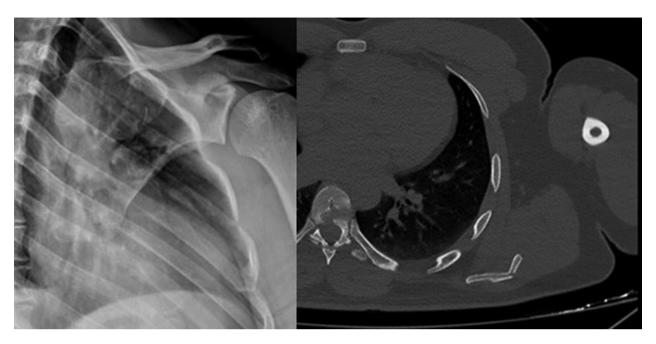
Left shoulder RX with an irregular rhyme of radiotransparency at the body level and the Left shoulder CT with displaced multifragmentary fracture of the body of the left scapula extending close to the inferior angle.
